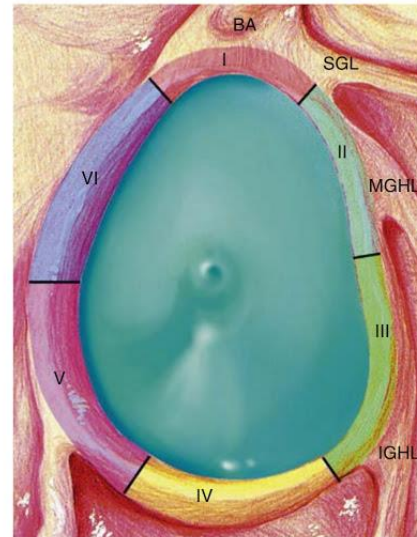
Labral “sectors”: I, superior; II, anterior superior; III, anterior inferior; IV, inferior; V, posterior inferior; and VI, posterior superior. BA, biceps anchor; SGL, superior glenohumeral ligament; MGHL, middle glenohumeral ligament; IGHL, inferior glenohumeral ligament. (From Zlatkin MB, Sanders TG. Magnetic resonance imaging of the glenoid labrum. *Radiol Clin North Am.* 2013;51(2):279–297.)
